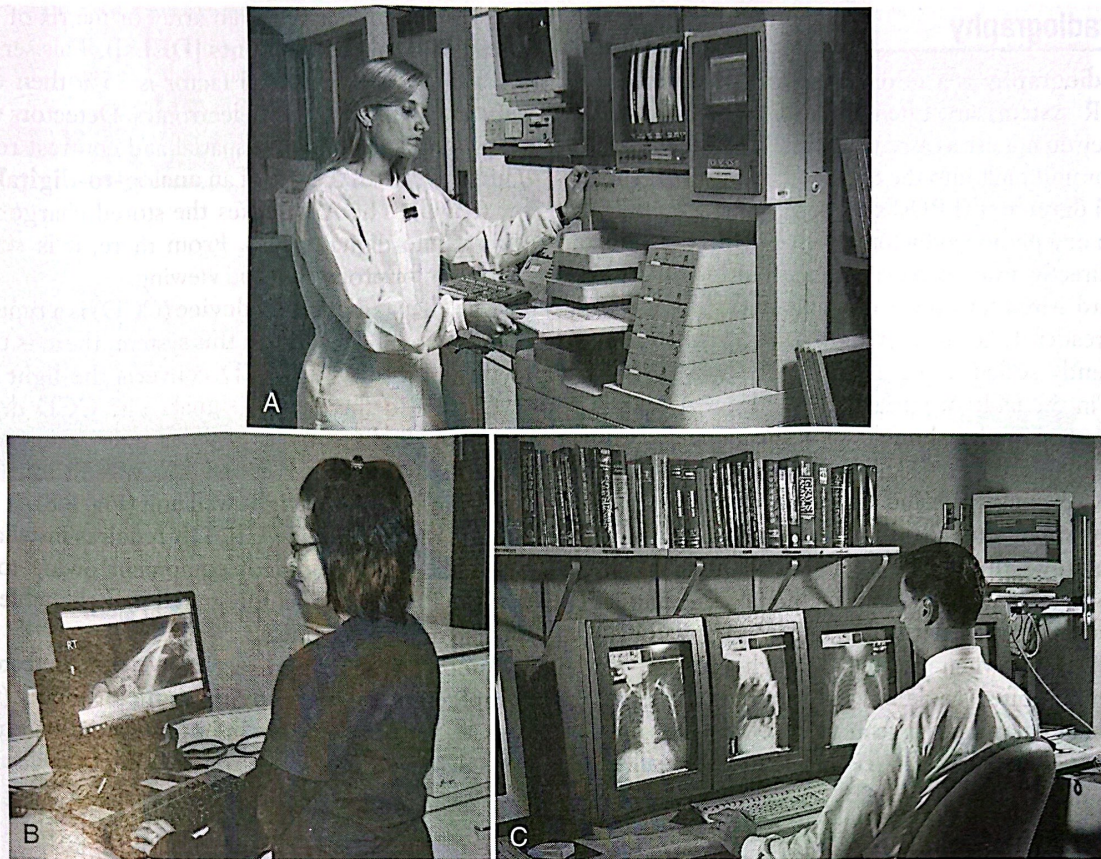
(A) Limited operator inserting an imaging plate (IP) into the computed radiography (CR) reader for processing of the image and plate erasure. (B) The operator's computer workstation. Here the operator checks the image for quality control, adjusts the image as required, and sends it electronically to the radiologist for interpretation. (C) The radiologist at the reading station. Note that several images can be viewed at one time. Images are retrieved from the department server for reading.
